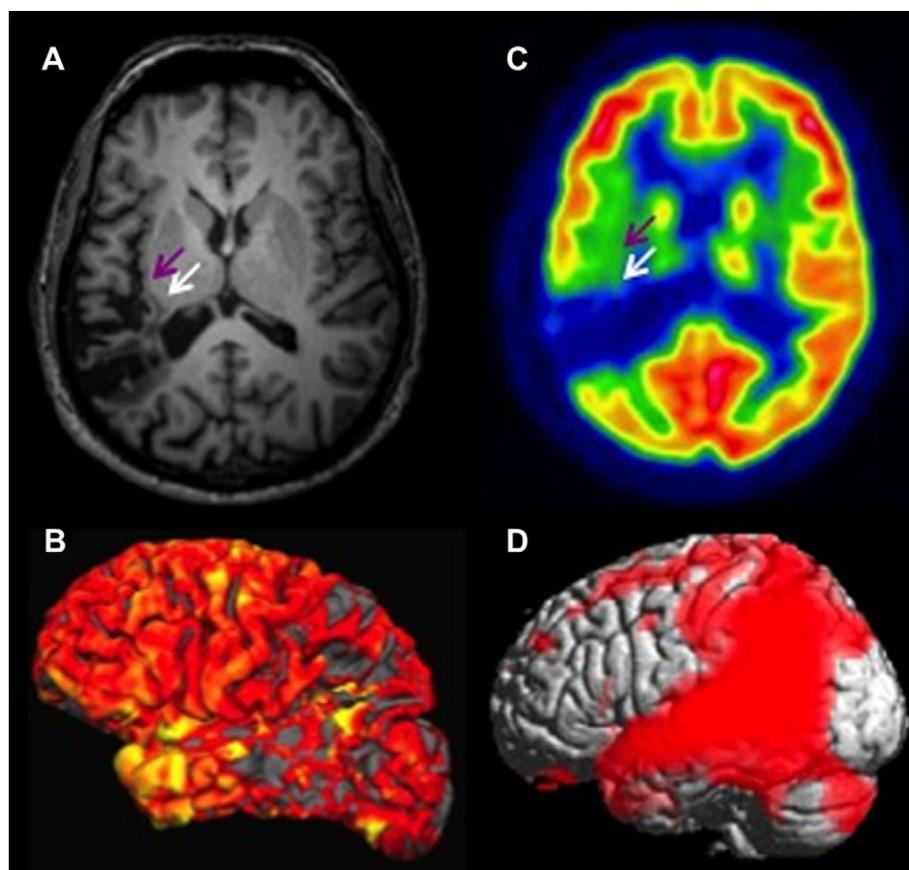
Structural and functional neuroimaging correlates of chronic repetition CA in a single case (patient AFR). (A) Structural 3-T MRI (axial plane) shows a left temporo-parietal infarction with subcortical extension into the AF (white arrow) and ventral stream in the posterior insular cortex (purple arrow). (B) Uninflated surface of the left hemisphere (FreeSurfer analysis) shows reduced cortical thickness (grey and yellow) in temporo-parietal regions. (C) ^{18}F -FDG-PET (axial plane) at rest depicting a focal area of decreased metabolism ($p < .001$ relative to 18 age- and gender-matched normal controls) affecting the left temporo-parietal cortex, AF (white arrow) and posterior insular cortex (purple arrow). (D) Brain surface rendering of ^{18}F -FDG-PET showing significantly decreased metabolism in the left hemisphere mainly affecting the left temporo-parietal cortex.
